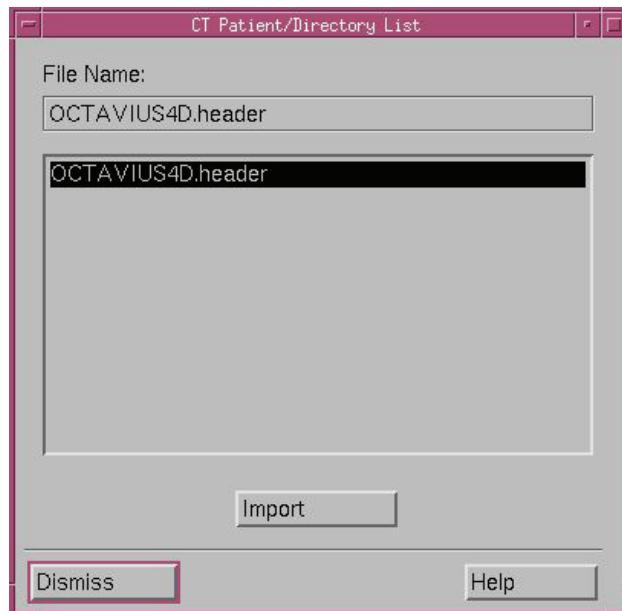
CT Patient/Directory List window.
